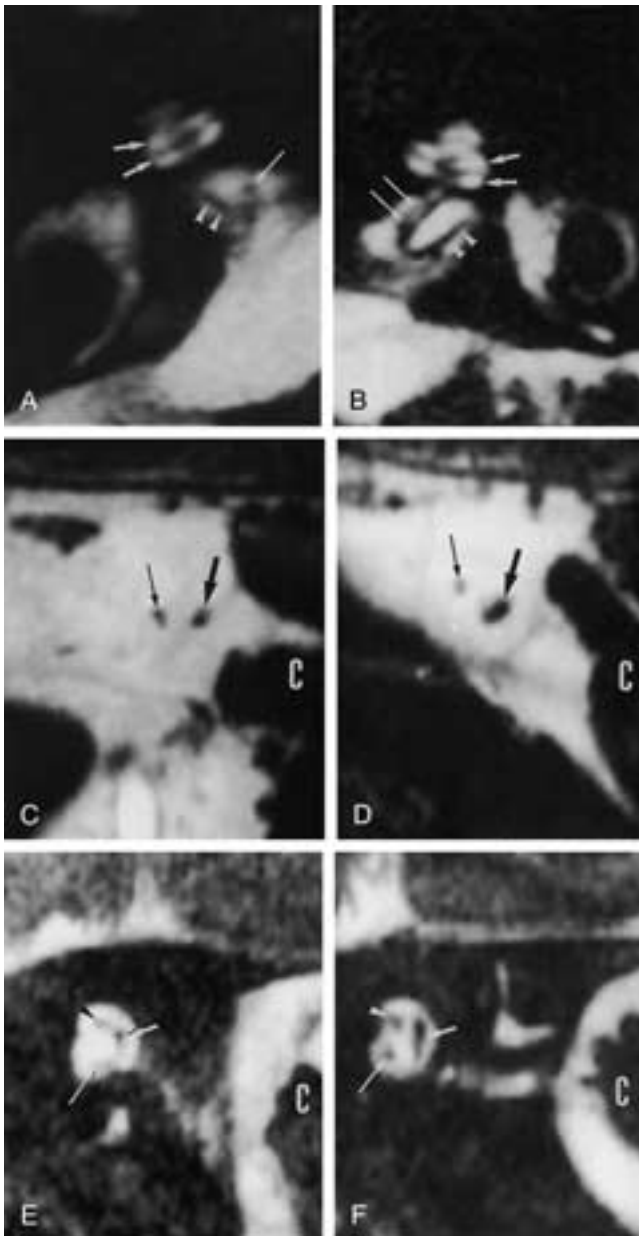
Type 2B malformation, hypoplasia of the cochlear branch of the right VCN in the presence of a normal labyrinth in a patient with severe but not complete congenital deafness on the right side. A and B, Axial T2-weighted gradient-echo images through the right (A) and left (B) IACs. A, A normal cochlea with distinguishable scala vestibuli/media and scala tympani can be seen (*small white arrows*). A normal-sized inferior vestibular branch (*white arrowheads*) can be seen, but the cochlear branch (*long white arrow*) of the VCN is hypoplastic. B, On the left side, both the cochlear (*long white arrows*) and inferior vestibular branches (*white arrowheads*) are normal in size. The scala vestibuli/media and scala tympani can again be distinguished in a normal-appearing cochlea (*small white arrows*). C to F, Parasagittal 3DFT-CISS reconstruction through the right (C) and left (D) cerebellopontine angles and through the right (E) and left (F) fundi of the IAC. C, The sizes of the facial nerve (*long black arrow*) and the VCN (*large black arrow*) are similar. Normally the VCN is one and a half to two times larger in diameter. The small diameter of the VCN corresponds with a smaller number of neuronal fibers in the “hypoplastic” nerve. D, On the normal left side, the VCN (*large black arrow*) is at least twice as large as the facial nerve (*long black arrow*). E, A hardly visible cochlear branch (*long white arrow*) and common undividing vestibular branch (*small white arrow*) of the VCN can be seen. The VCN therefore is hypoplastic. The facial nerve has a normal size (*black arrowhead*). F, On the left side, a normal facial nerve (*white arrowhead*) and a normal-sized cochlear branch (*long white arrow*) and dividing common vestibular branch (*small white arrow*) of the VCN can be seen. C, Cerebellum.
